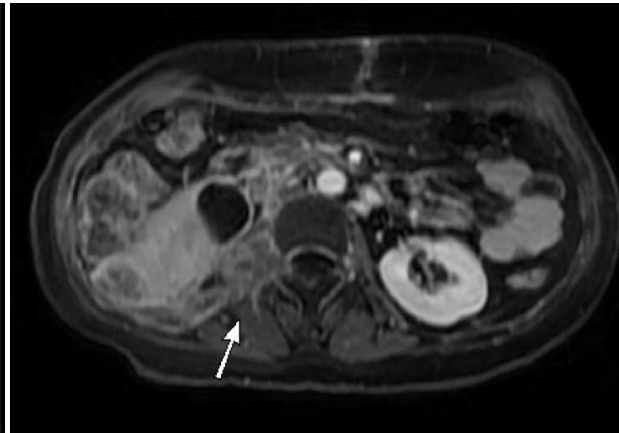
Contrast-enhanced renal MRI. Recurrence in the surgical bed with extension into the spinal canal.
